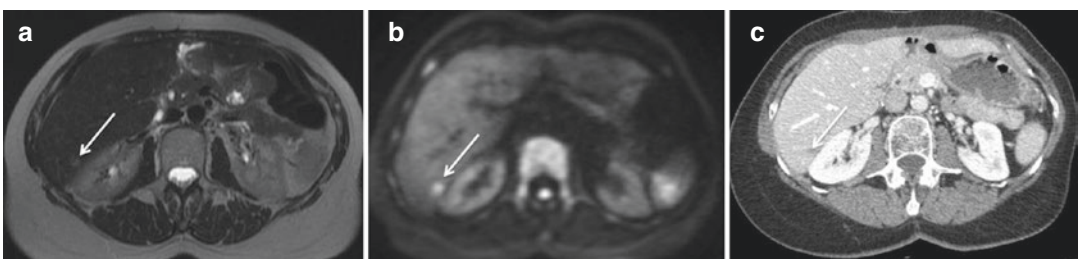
Axial T2-weighted MR image (a) and contrast CT scan (b) show a vague T2 hyperintense (a) and CT hypodense (c) lesion within the liver surface which is easily
